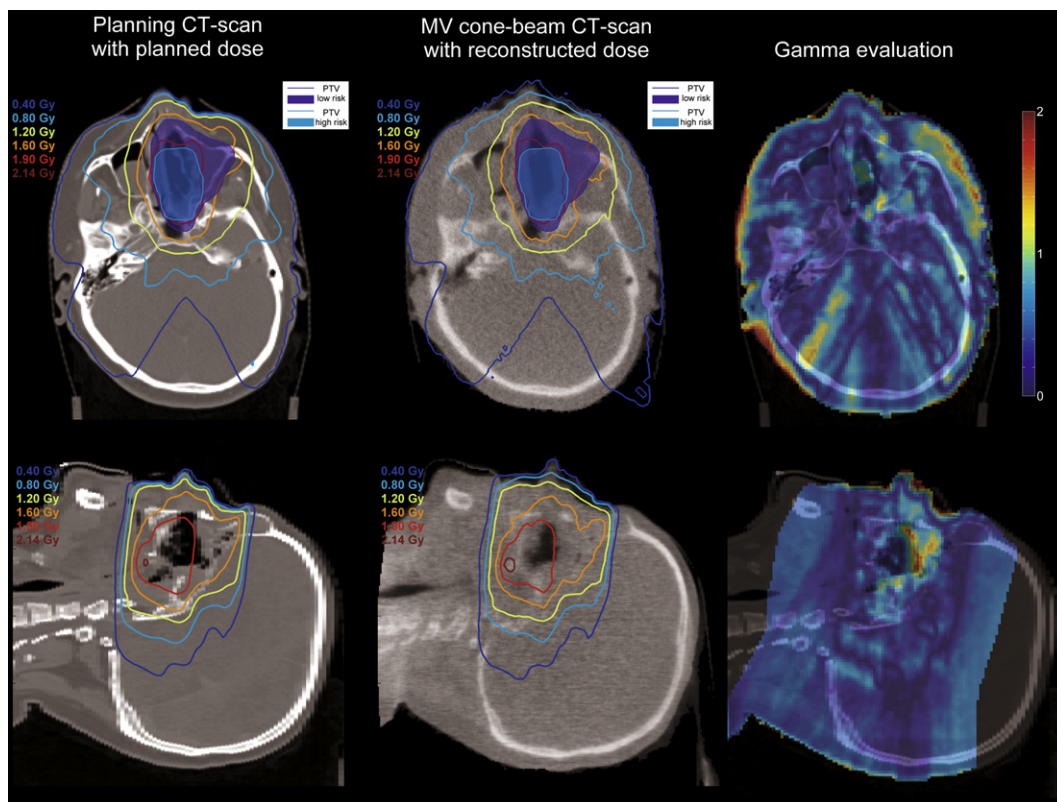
The planned dose distribution projected on the planning CT scan together with the delivered dose distribution calculated on the megavoltage-cone-beam CT scan acquired at the seventh treatment fraction. The exit dose of each treatment beam is measured with the EPID and back-projected through the patient to calculate the input fluence, which is used by an independent Monte Carlo dose calculation engine to calculate the delivered dose distribution in the cone-beam CT. The right column shows gamma images (3%/3 mm distance to agreement). This method allows the calculation of the actual delivered dose distribution in 3D. This figure was published previously in reference [82]. See power point version of the figure in the Supplementary data.
